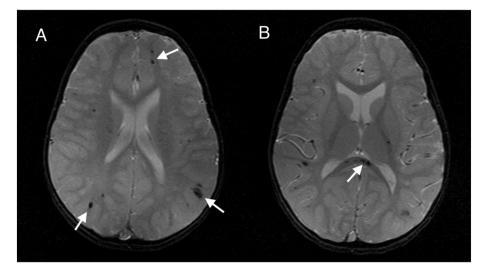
Magnetic resonance images (MRI) of the brain, in axial section, on the gradient echo (GRE) sequence, showing;
